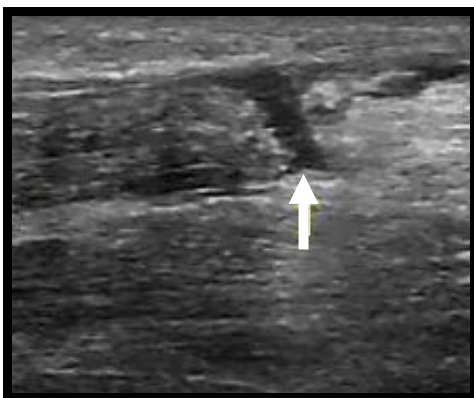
Ultrasound. B-mode.
